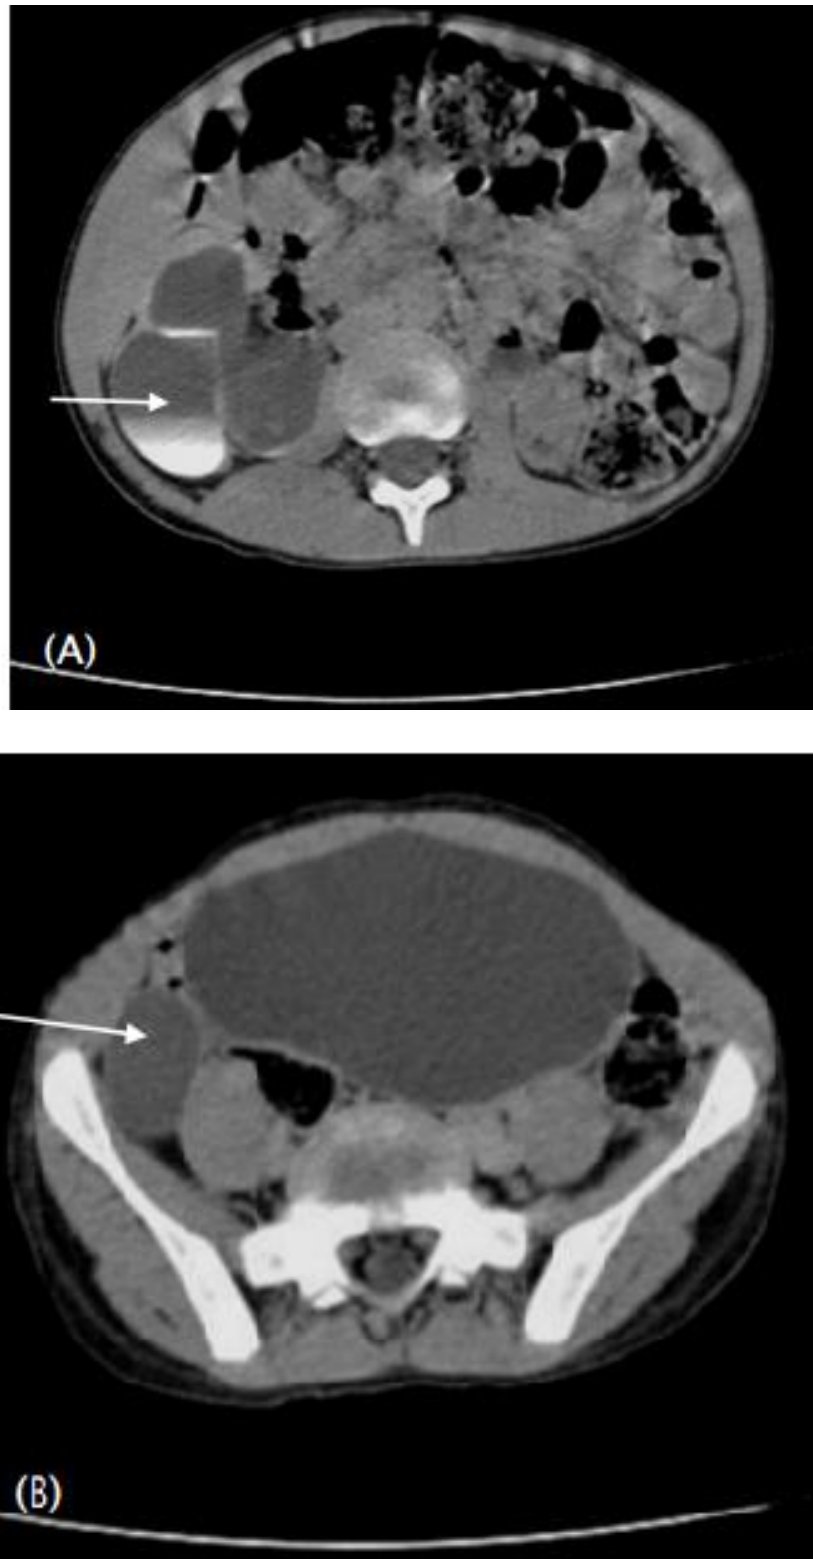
CT of the kidneys on a patient with right refluxing megaureter.
